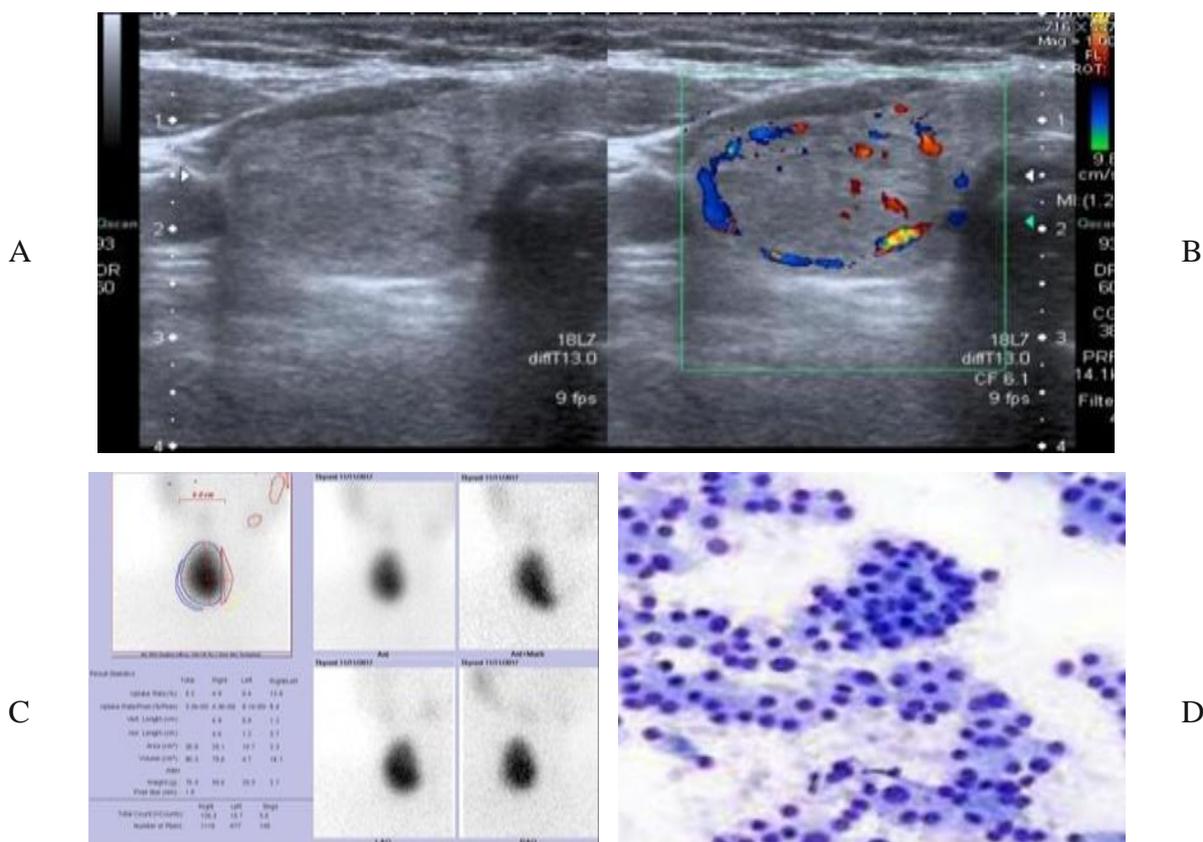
Fifty three 53 years old female, A; US image showed well-defined iso-echoic right lobe solid nodule. B; Doppler image displayed peripheral & central vascularity. C: Thyroid scan image, oval shaped intense adenoma with suppression to rest of the gland & uptake = 5.2%. D; Cytological findings of FNAB demonstrating, follicular adenoma with mature follicular cells and bland looking nuclei.
